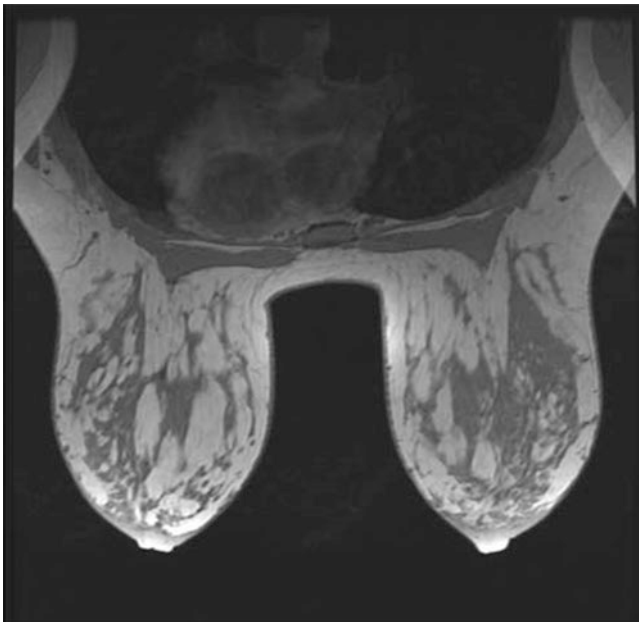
Breast MR image
